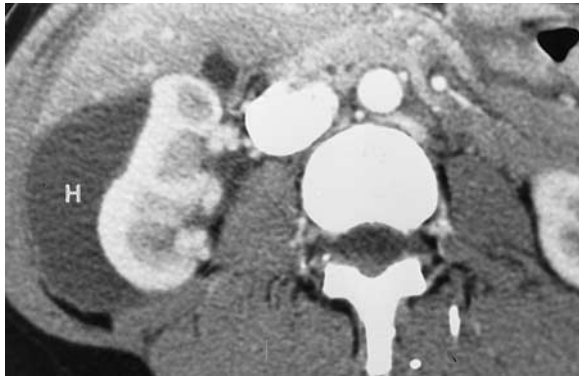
Subcapsular hematoma (Page kidney) in a 30-year-old woman with a history of a seizure disorder who presented with right flank pain and hypertension. Contrast-enhanced spiral CT scan demonstrates a subcapsular fluid collection (*H*) flattening the right kidney. The patient underwent successful US-guided percutaneous drainage of the hematoma.
